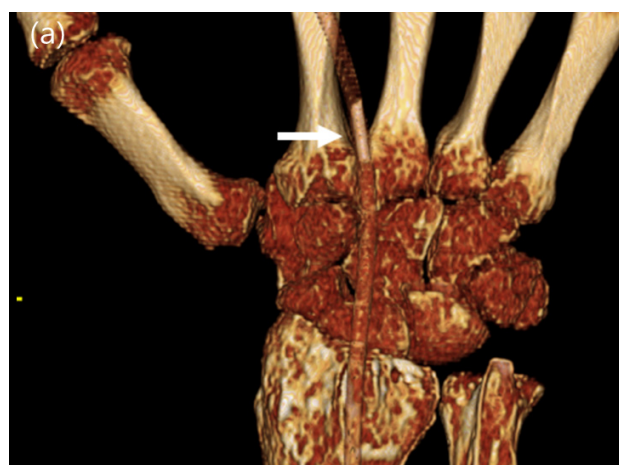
Three dimensional volume rendering of the CT data performed at the time of the study clearly demonstrates an IV catheter fragment (arrow) in the venous catheter (A). MIP view displays an IV catheter fragment (arrow) in the IV flow control line (B)
